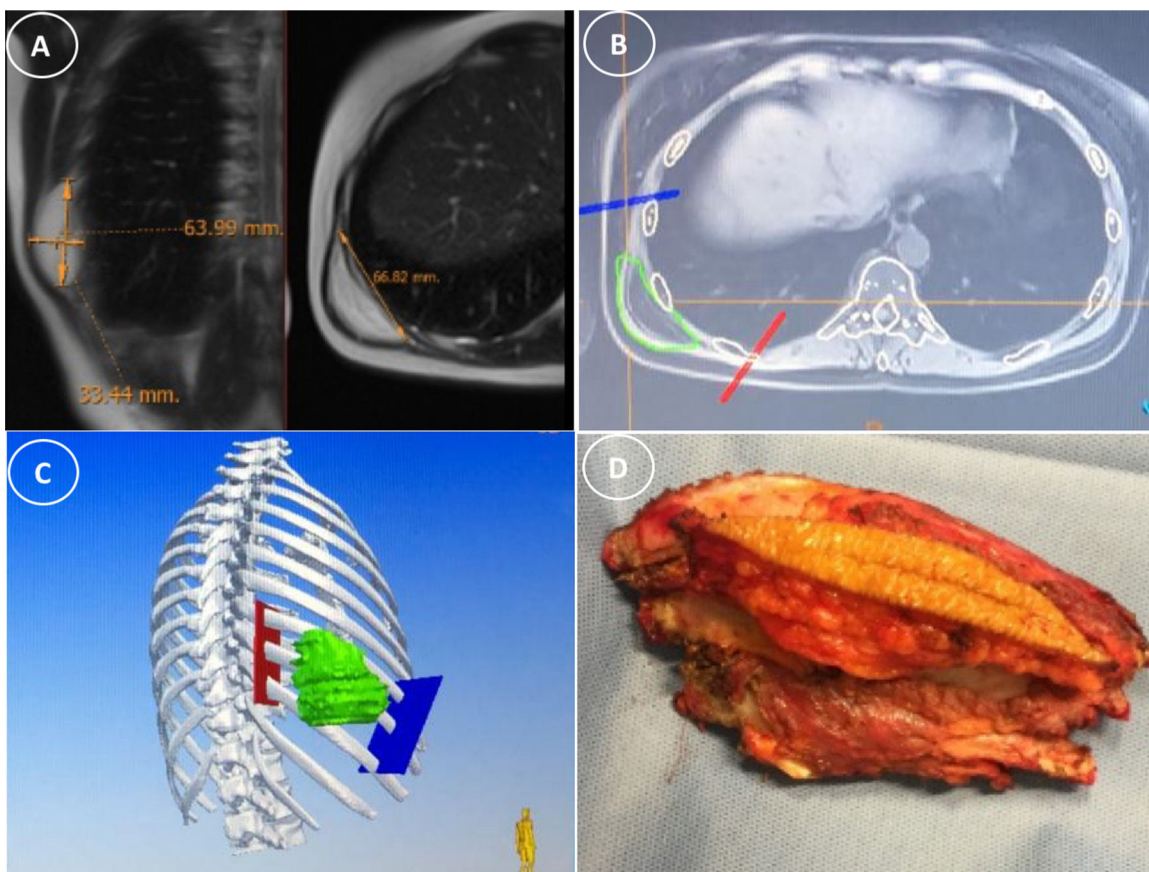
A) Magnetic resonance imaging (MRI) of the patient's chest before the initial surgery. B) Tomographic reconstruction of the original injury generated from the MRI. C) Intraoperative navigation. D) resection.
